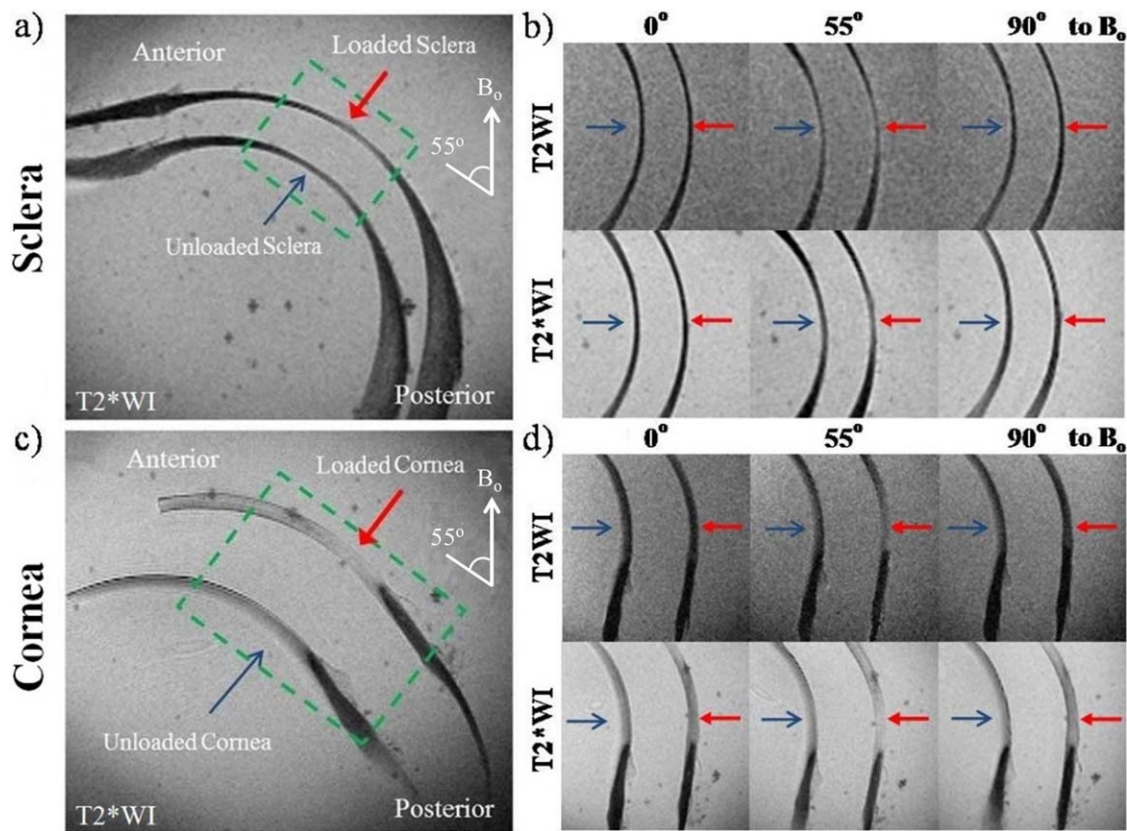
(a, c) T2*-weighted MR images (T2*WI) of the unloaded (blue arrow) and loaded (red arrow) sclera (a) and cornea (c) tissue sections at the magic angle at approximately 55° to the main magnetic field (B_0); (b, d) T2-weighted images (T2WI) and T2*WI of the sclera (b) and cornea (d) enlarged from the green dashed boxes in (a, c) when the ocular tissues were oriented and scanned at 0°, 55°, and 90° to B_0 under the same MRI acquisition parameters as the tendon controls in Figure 6. Magic angle signal enhancement was observed in both T2WI and T2*WI of the sclera and cornea. Stronger signal enhancement was observed in the loaded tissues than unloaded tissues (repetition time = 1 s; echo time = 9.7 ms; in-plane resolution = $110 \times 110 \mu\text{m}^2$).
